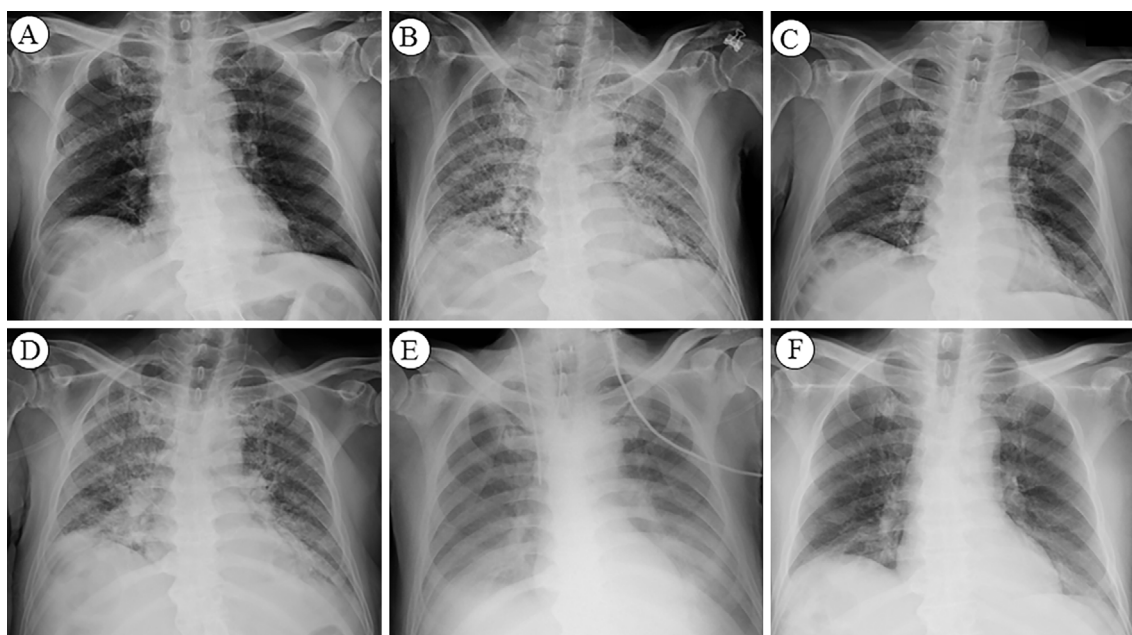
Chronological chest radiographs obtained after the 1st and 2nd episodes of TRALI. (A) The lungs were normal on the morning of day 9 of chemotherapy. (B) Nine hours later, TRALI occurred after a platelet transfusion. (C) The next day, the TRALI spontaneously resolved. (D) On day 12 of the chemotherapy, TRALI occurred again after a platelet transfusion. (E) The next day, the patient's pulmonary edema was ameliorated via mechanical ventilation. (F) On day 16 of the chemotherapy, the patient's lungs were nearly normal.
